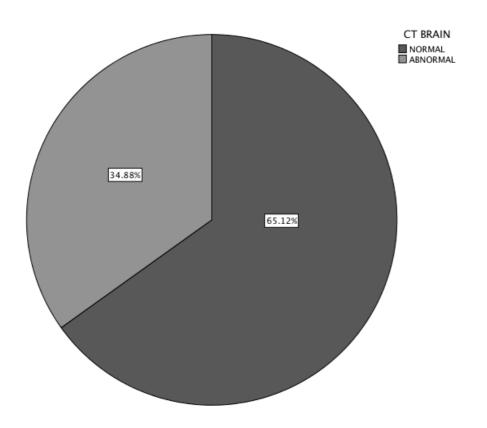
Pie Chart showing CT Brain finding in the study population.
